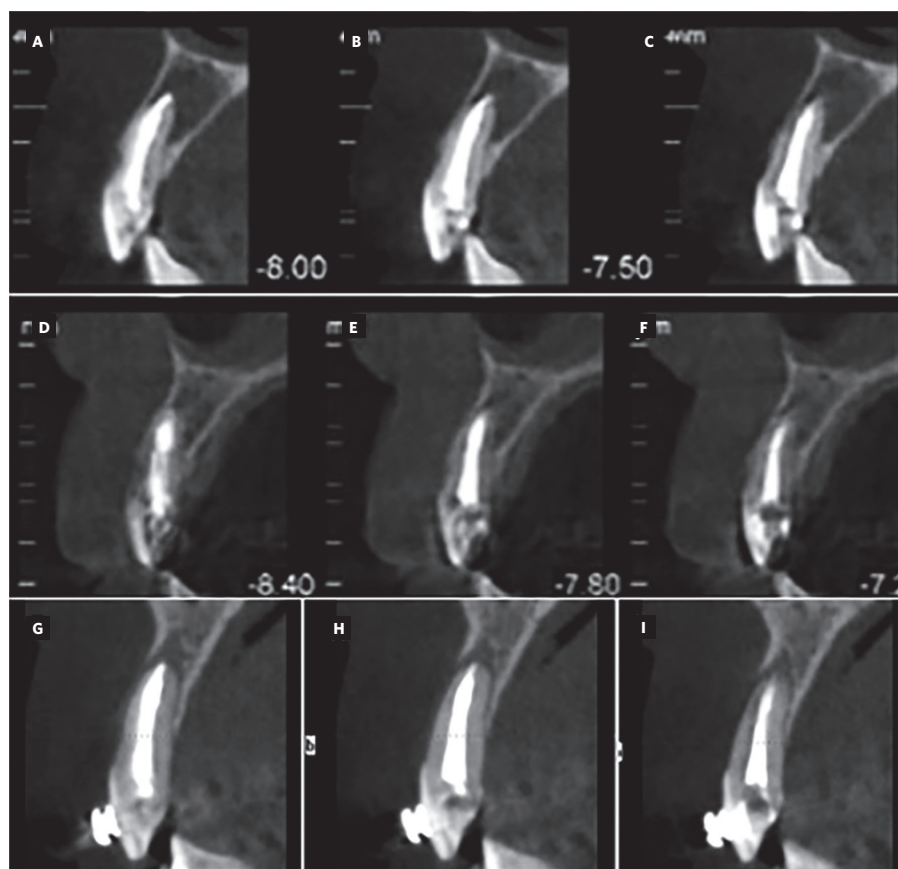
Cone beam tomography with cuts in the vestibule-palatal direction every 0.5 mm. (A, B, C) Initial lesion. (D, E, F) 6 months post treatment. (G, H, I) 24 months after treatment, imaging evidence is observed of complete bone regeneration, with a small area of less apical radiopacity compatible with a fibrous scar.
